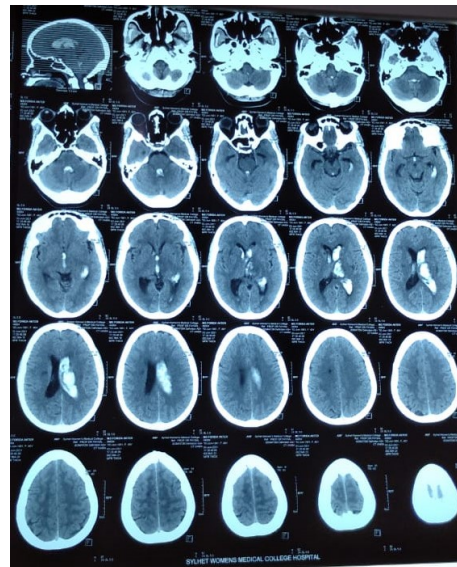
CT scan of brain shows intraventricular hemorrhage.
